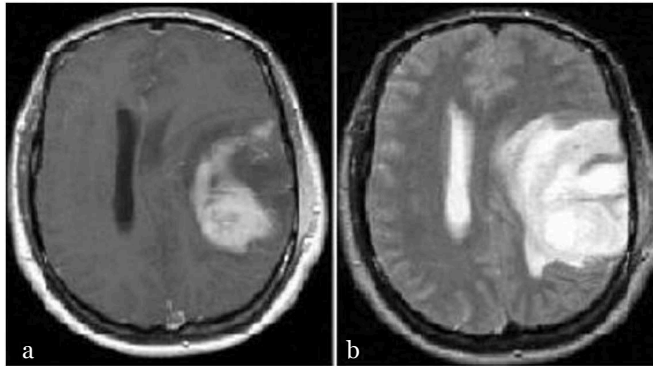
Large GBM presenting a large mass lesion, (a) with strong enhancement, and (b) a heterogeneous signal pattern on T2-weighted MRI.
